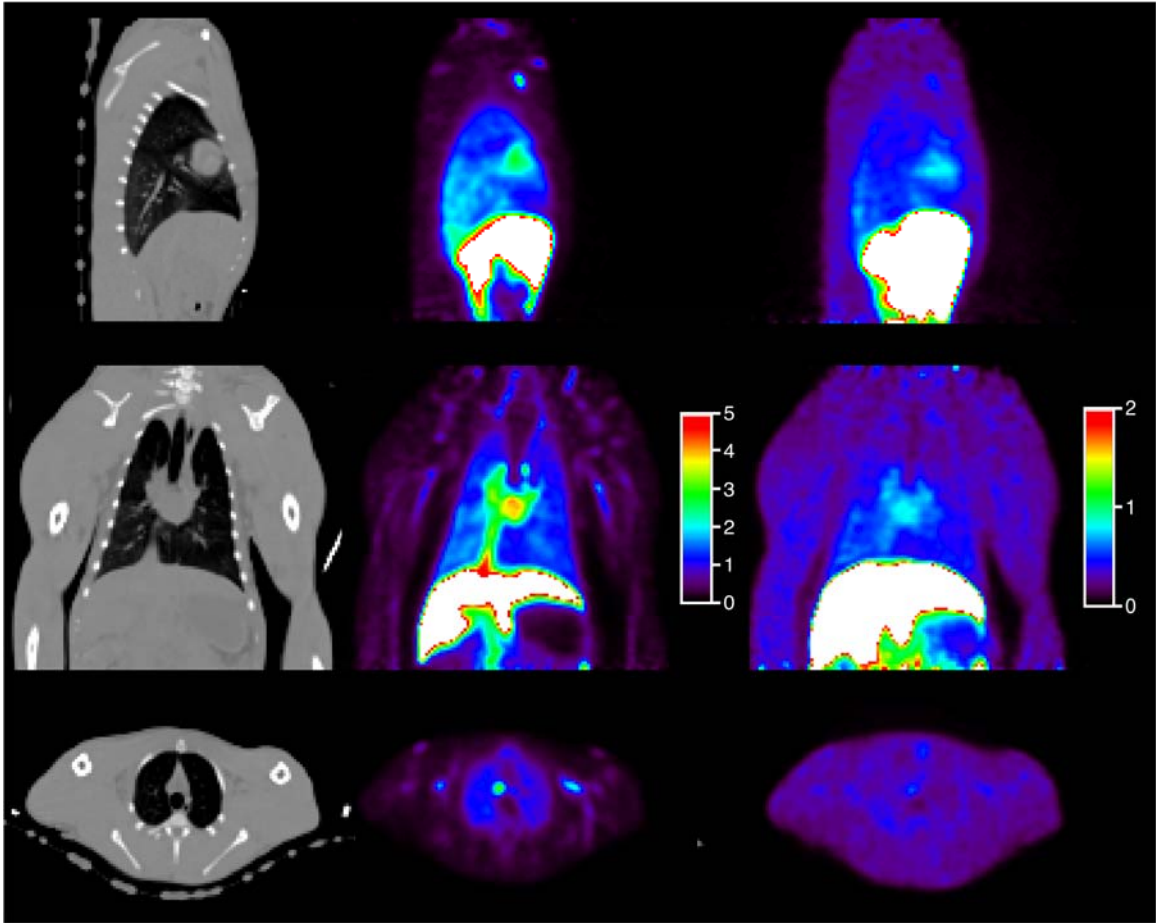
Images of ^{11}C -BMT-136088 distribution: CT images (left), early (0-5 min post injection, center) and late (40-60 min post injection, right) distribution, expressed in SUV, in sagittal, coronal and transverse views (from top to bottom).
